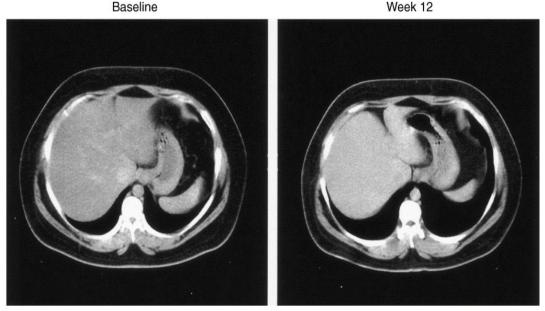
Single cross-sectional images of the liver performed by computed tomography at baseline and week 12 of a very-low-energy diet. The images, taken from within a series of contiguous 8-mm slices used to calculate total liver volume. Hastrate the extent of the change in liver volume with weight loss in a 35-y-old man with an initial liver volume of 3.7 L and a final liver volume of 2.4 L. A 35% reduction in liver size and weight loss of 18 kg were observed.
